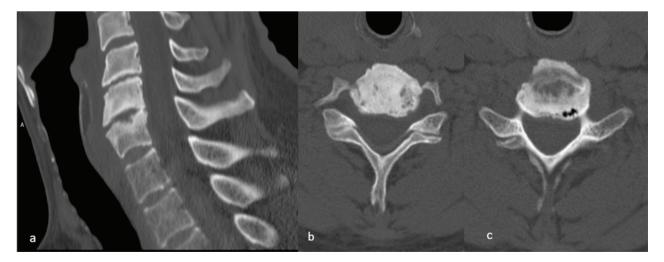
Preoperative CT scan of C6-C7 segment showing reduction of C6-C7 disc height, anterior osteophytotic degeneration of vertebral bodies, initial posterior ankylosis of C6 and C7 vertebral plates (a), sclerosis and little erosion of inferior C6 (b) and superior C7 vertebral plates (c).
